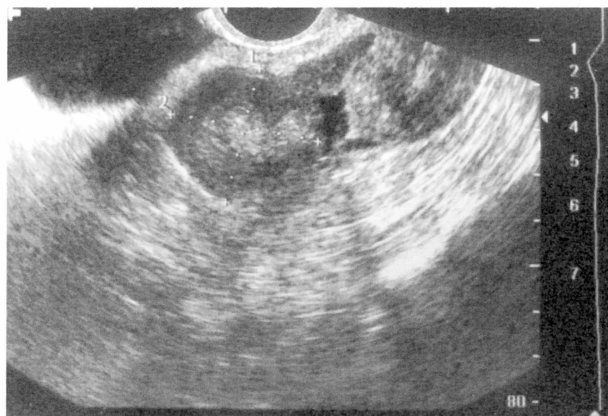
Preoperative ultrasonography revealed primary fallopian tube carcinoma mimicking a tubo-ovarian abscess.
